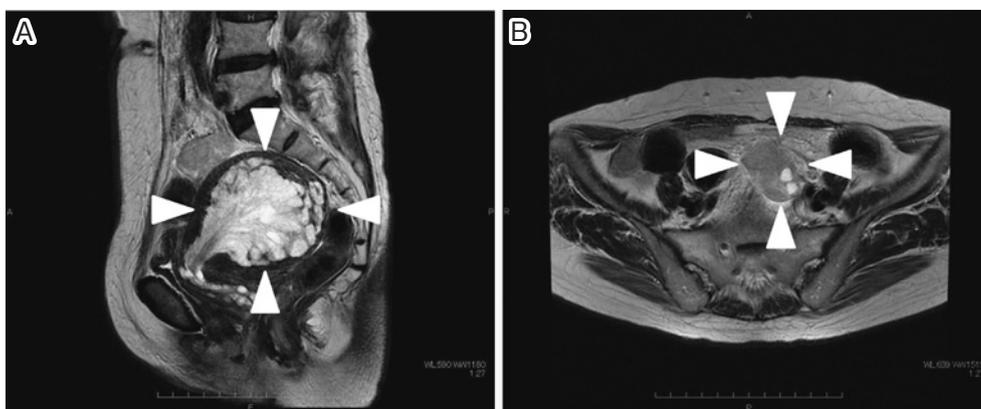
T2-weighted magnetic resonance images of the pelvis.
